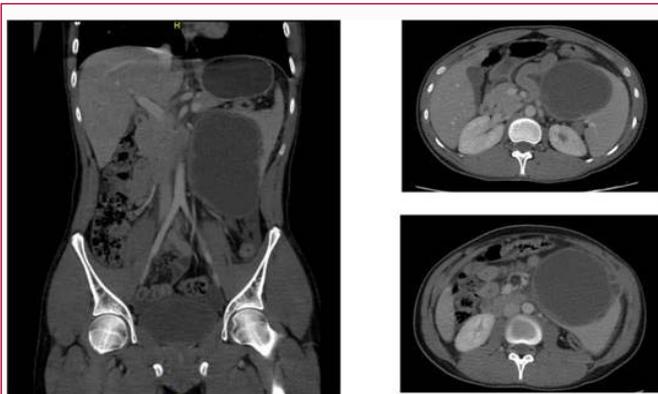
CT scan of the abdomen showed a large cystic lesion on the spleen measuring 15 cm × 9 cm × 8.5 cm in craniocaudal, transverse, and anterior-posterior dimensions respectively.
